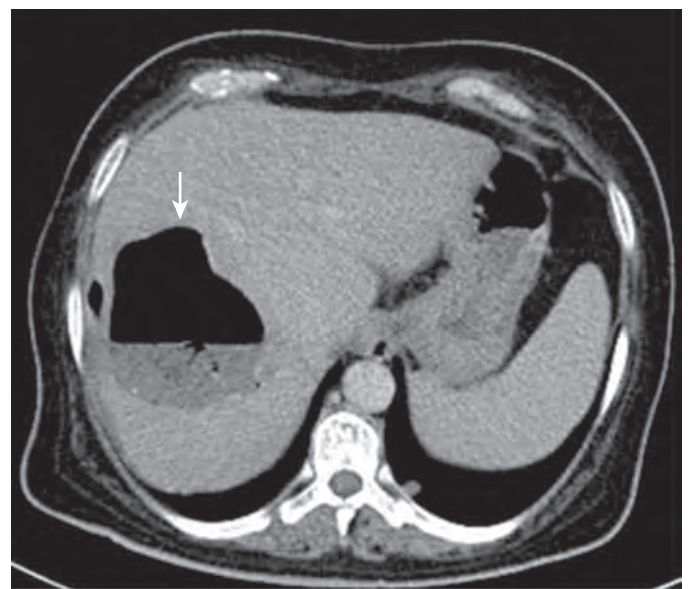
Hydatid disease: CT findings. A large infected hydatid cyst (arrow) that shows an air-fluid level on the contrast-enhanced CT image.
